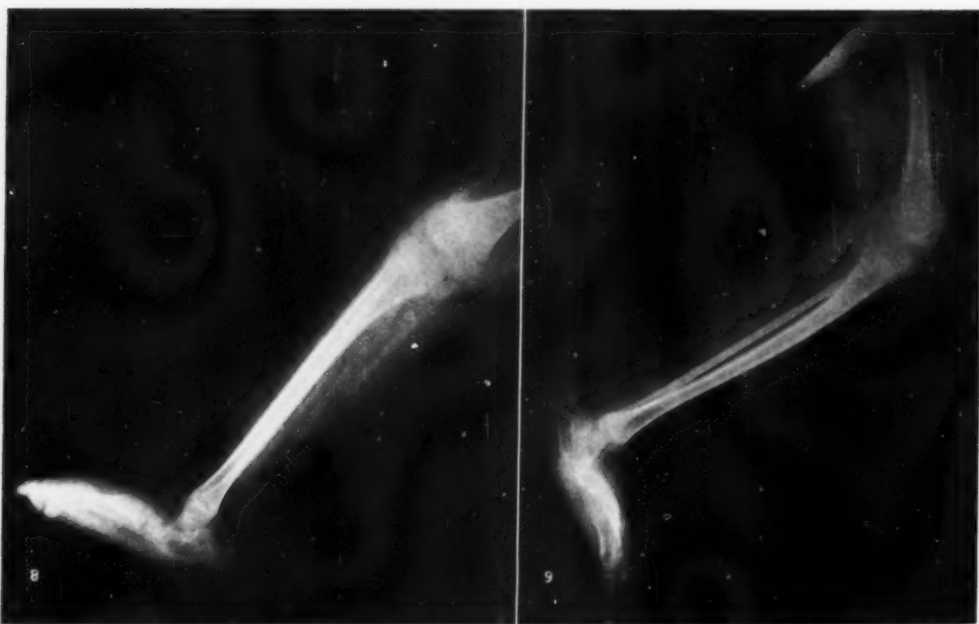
Lateral roentgenogram of right leg in Case 1, clearly outlining the thin muscle bundles and the osteoporosis. Valgus of the heel seen in this view. An extension contracture of the knee is present.
